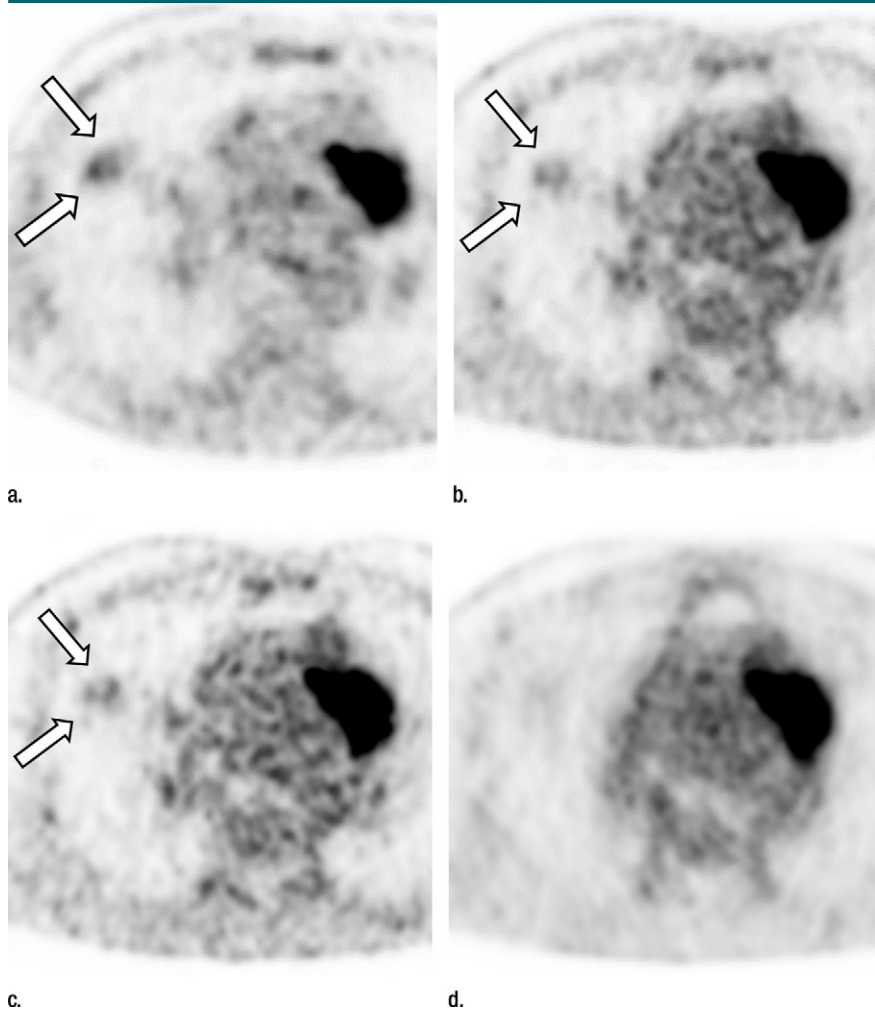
Images in 67-year-old man with lung cancer (arrows). (a) Axial PET image from TOF-PET/CT (standard of reference), (b) 70% of the standard dose (reduction of up to 30%) with TOF, (c) 40% of the standard dose (reduction of up to 60%) with TOF, and (d) 70% of the standard dose without TOF are shown. PET/CT and PET/MR were performed 94 and 58 minutes after FDG injection, respectively. On c, the PET image with 40% of the dose, the tumor (arrows) is visible, whereas on d, the non-TOF PET image with 70% of the standard dose, the tumor is no longer detectable.
